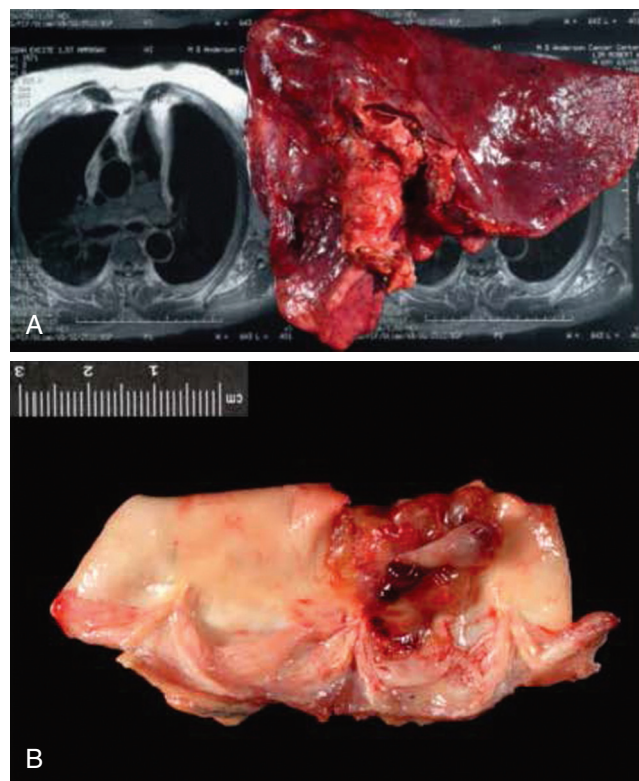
■ Pulmonary artery sarcoma. A, Pulmonary artery sarcoma overlying computed tomographic scan. B, Pulmonary artery sarcoma starting at pulmonary valve.
